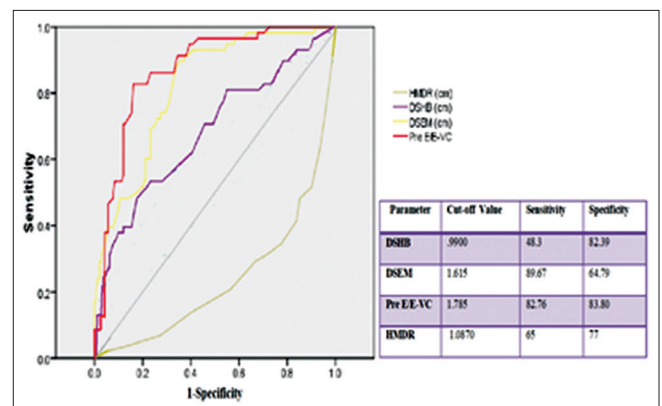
Graphical representation of predictive value of sonographic measured airway parameters in assessing difficult laryngoscopy utilising receivers operating curve. HMDR: hyomental distance ratio, Pre E/E-VC: ratio of depth of epiglottic space to the distance b/w epiglottis and midpoint of vocal cords, DSHB: distance from skin to hyoid bone, DSEM: distance from skin to epiglottis b/w thyroid cartilage and hyoid bone
